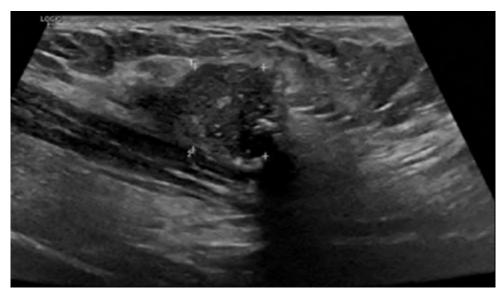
Ultrasound of left anterior cervical region.
